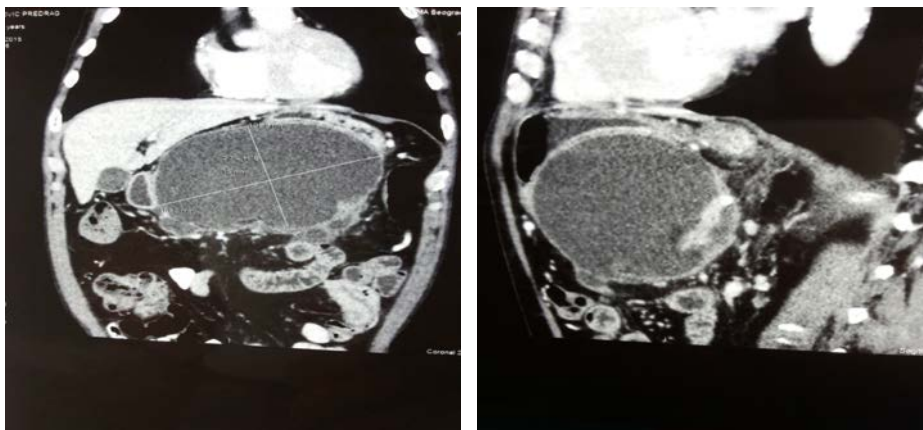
Computed tomography (CT) scan with the pancreatic pseudocyst (PPC) in the region of pancreatic body and tail.
